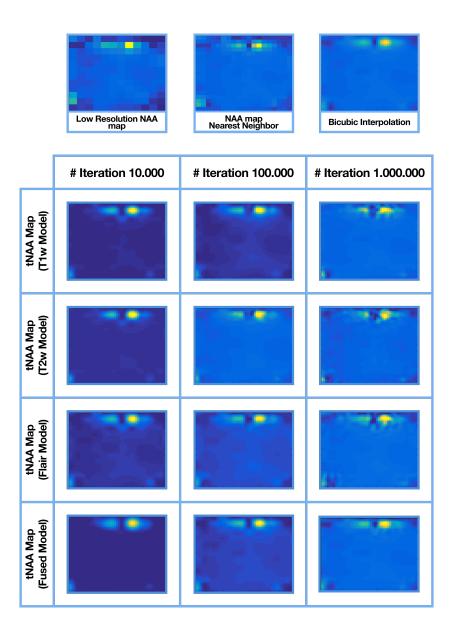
SRCNN results of an example tNAA map upscaled by using T1w, T2w, FLAIR, and Fused MRI filter models with 10.000, 100.000, and 1.000.000 iterations
